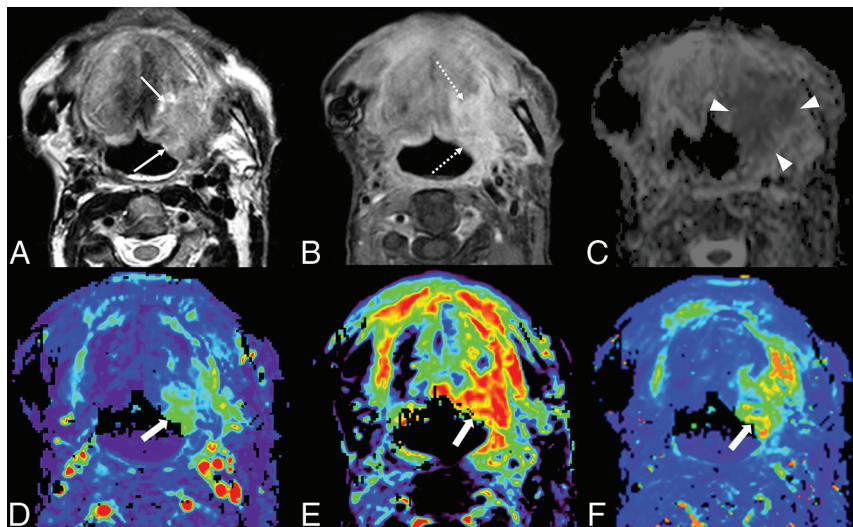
A case of head and neck cancer recurrence. A 72-year-old man after an operation and radiation therapy for squamous cell carcinoma of the floor of the mouth. The left side of the floor of the mouth shows some high signal intensity (arrows) on T2WI (A) and mild enhancement (dotted arrows) on postcontrast fat-suppressed T1WI (B). The ADC map (C) shows low signal (arrowheads), with an $nADC_{mean}$ of 1.38. DCE-MR imaging (D, Vp ; E, Ve ; F, K^{trans}) shows increased parameters (thick arrows), with an nVp of 7.33, nVe of 3.93, and nK^{trans} of 5.44.
